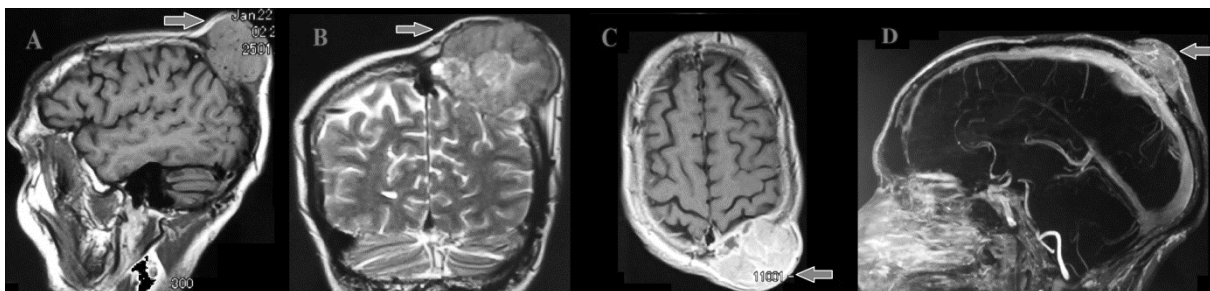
Preoperative brain MRI. A: T1 weighted imaging sagittal; B: T2 weighted imaging coronal; C: T1 enhanced; D: Angio MR, showing that the tumor is limited at skull plan without brain invasion and its hyper vascularization nature
